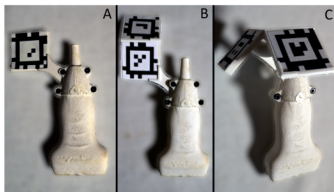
Different designs for attaching Apriltag flags to an ultrasound probe.
